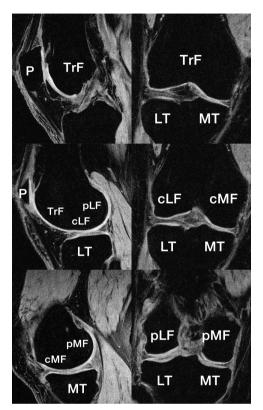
Anatomical labels of knee joint cartilage plates. Sagittal images (left row) and coronal images (right row). Figure and figure legend from: Eckstein F, Ateshian G, Burgkart R, Burstein D, Cicuttini F, Dardzinski B, et al. Proposal for a nomenclature for magnetic resonance imaging based measures of articular cartilage in osteoarthritis. Osteoarthritis Cartilage 2006; 14(10): 974-83. With kind permission of the authors and publisher.
